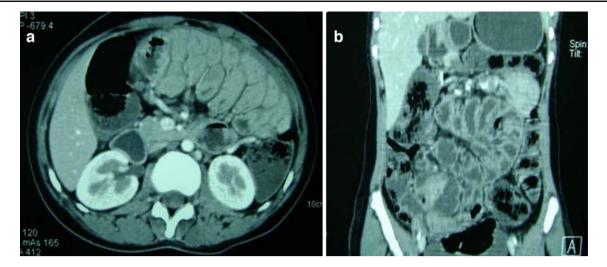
a, b Contrast-enhanced CT images show congregated small gut loops confined to a single area and encased in a thick membrane.
